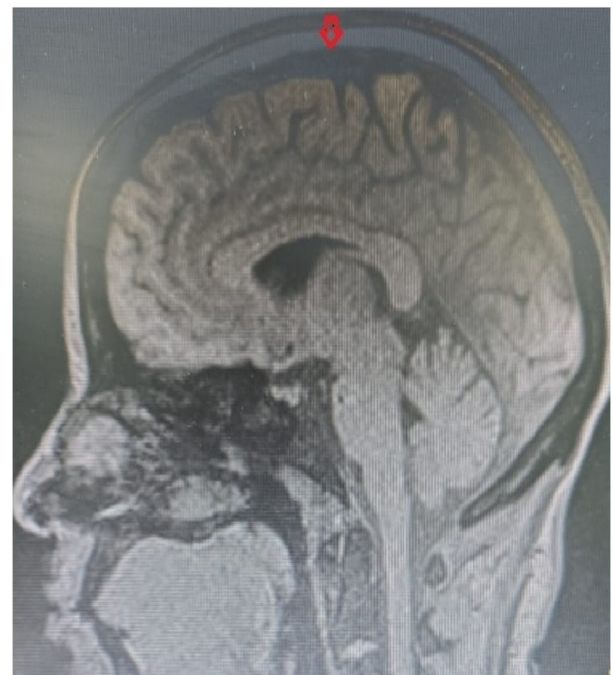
Follow-up image. MRI T1-weighted sagittal view of the brain. The arrow shows normal flow voids in the superior sagittal sinus. Image was obtained in June 2024.
